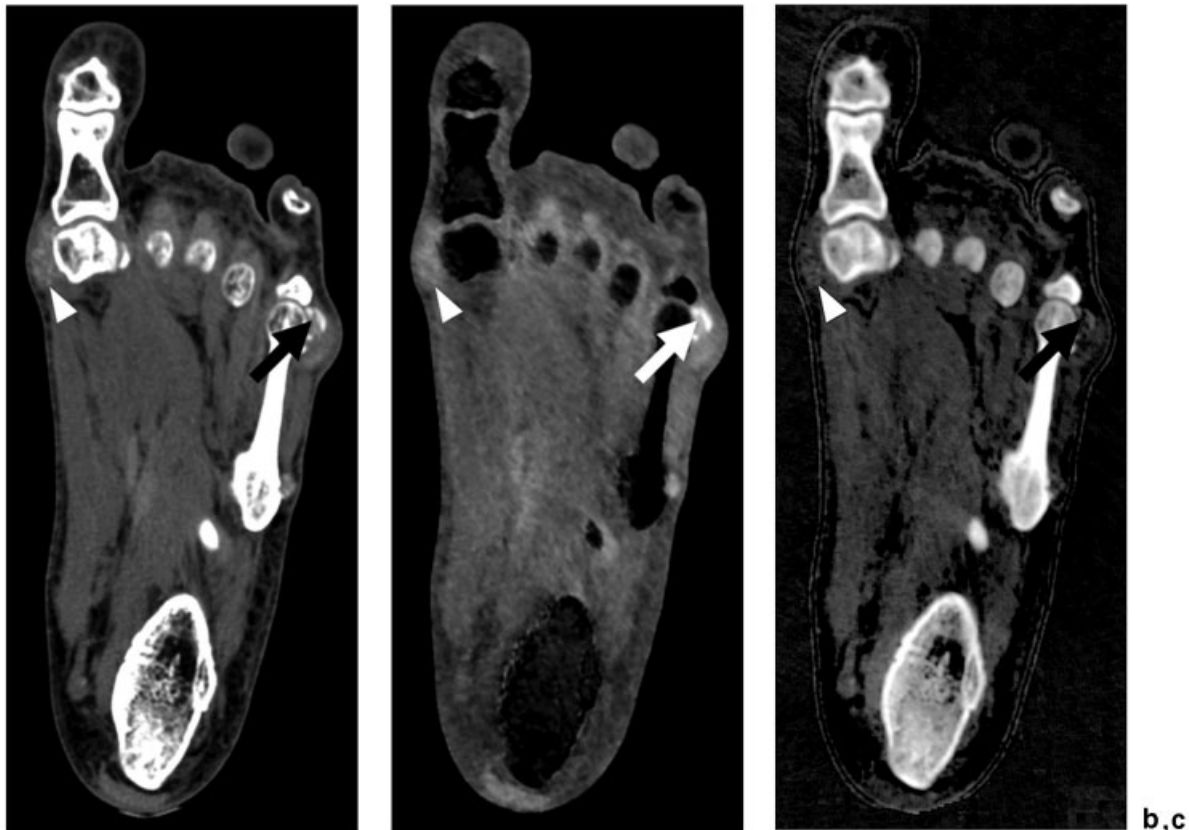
A 35-year-old man referred by an orthopedic surgeon for acute pain and swelling in his left foot. (a) Conventional polychromatic computed tomography (CT) image shows indeterminate soft tissue masses around the first (arrowheads) and fifth (arrows) metatarsophalangeal joints, as well as the base of the fifth metatarsal bone, with CT numbers ranging from 150 to 200 HU and suggestive of gouty tophi. Basis-material (uric acid [b] versus calcium hydroxyapatite [c]) decomposition of dual-energy computed tomography data confirm the diagnosis of acute gout, with monosodium urate deposits of variable densities (arrows and arrowheads) visible on uric acid maps (b) and little calcium seen on the corresponding calcium hydroxyapatite images (c).
